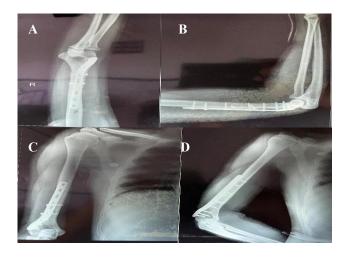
(A-D): X-rays at subsequent monthly follow ups.
